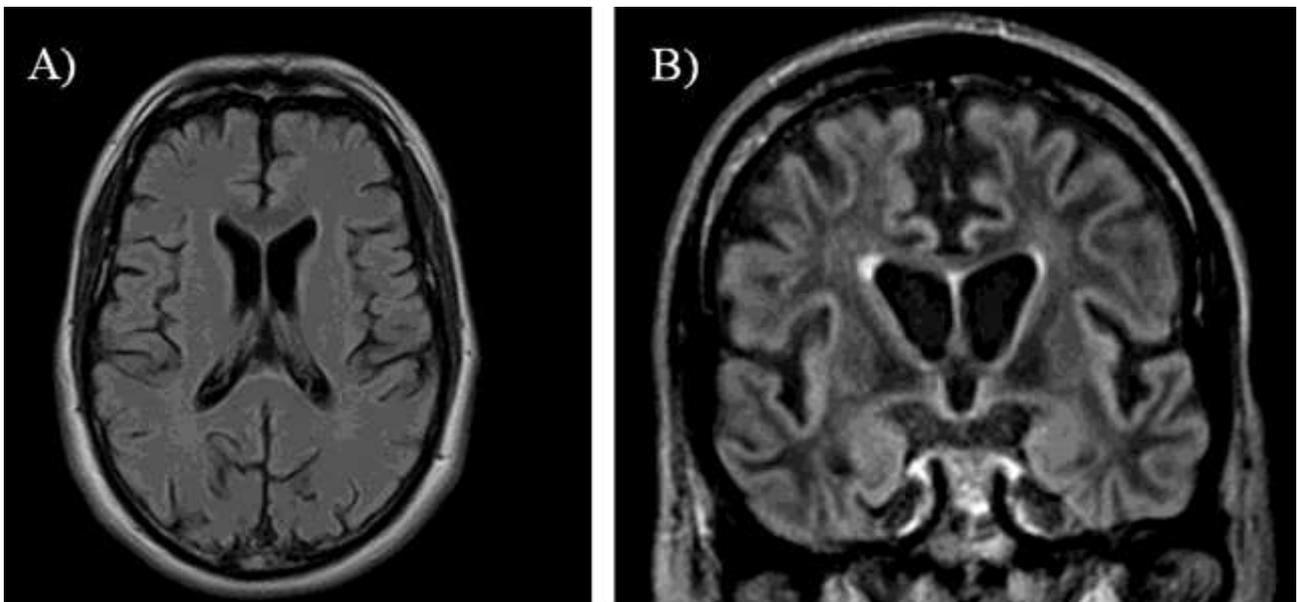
Brain magnetic resonance imaging T1-w axial (A) and fluid attenuated inversion recovery coronal (B) images of patient 21. Image in (A) was obtained at the age of 53 (after 5 years from disease onset) and showed very mild anterior cingulate atrophy. Image in (B), at 59 years old, showed widespread cortical atrophy prevalent in the cingulate cortex.
